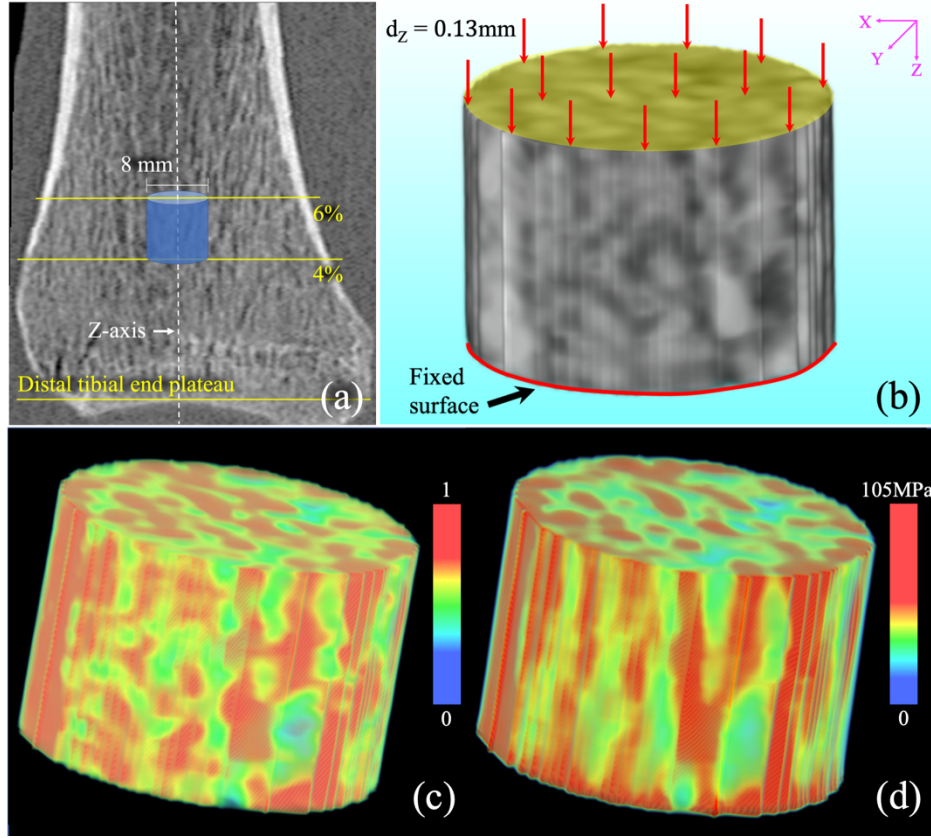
Multi-row detector CT-based FE modelling and computation of trabecular microstructural strength. (a) A sagittal image slice from a distal tibia MDCT scan; the cylindrical ROI for FEA is shown in blue. (b) FEA boundary condition and loading protocol on the extracted Tb core. (c) Color-coded volume rendition of the normalized BMD map over the ROI of (b). (d) Same as (c) but for FEA recorded von Mises stress.
